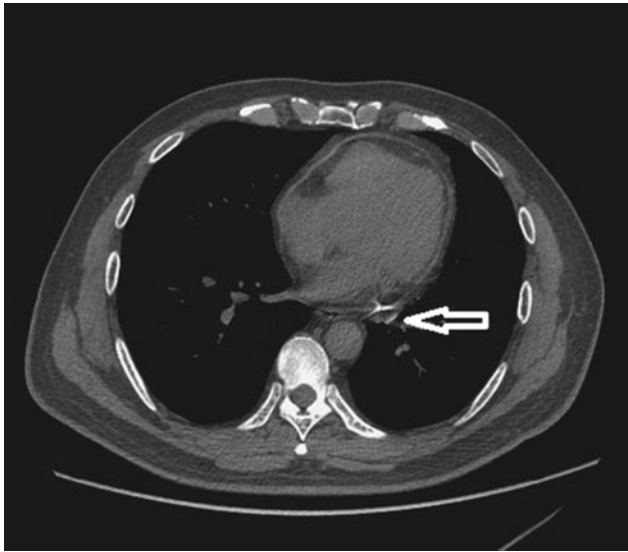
CT showed widely thickened pericardium with mild calcification (indicated by arrow)
